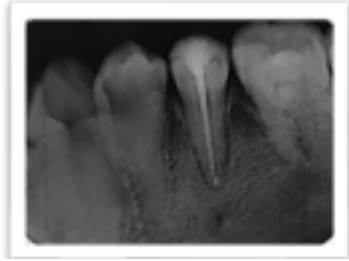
Trial Periapical photo of 35
